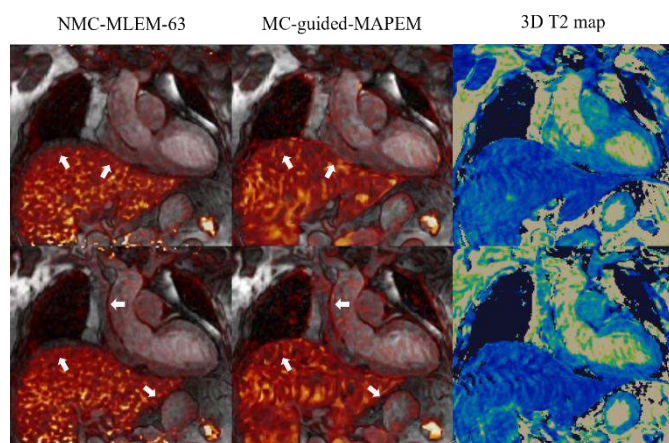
Fused PET-MR image, showing the conventional no motion correction maximum-likelihood expectation-maximization reconstruction and the proposed motion corrected MR-guided maximum a posteriori expectation maximisation. Third column shows the corresponding 3D T₂ maps. Improvements in the correspondence between PET and MR are highlighted with the white arrows.
